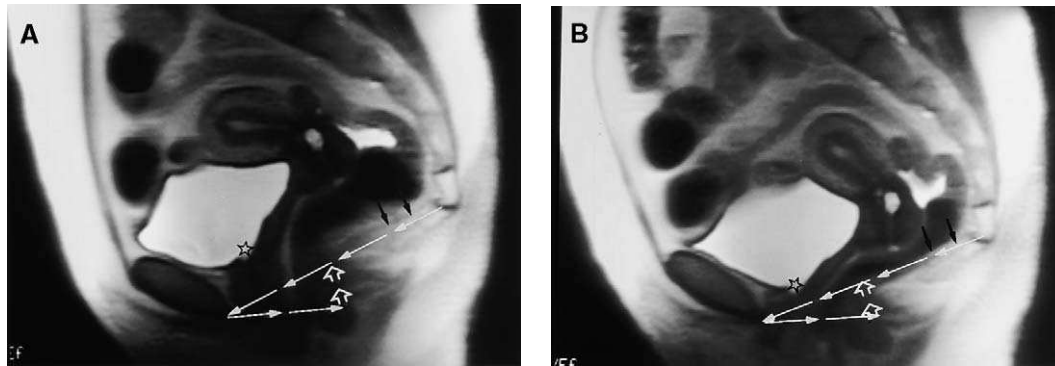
T2-weighted (2200/96) pelvic MR image of a 46-year-old healthy, continent volunteer. Sagittal images of the subject at rest (A) and at strain (B) show minimal inferior movement of the pelvic viscera. The bladder neck is marked with a star. The levator plate (black arrows) remains parallel with the pubococcygeal line (upper line of white solid arrows). The H (lower line of white solid arrows) and M (open arrows) lines are less than 5 cm and 2 cm, respectively, which indicates an intact levator hiatus. (From Fielding JR. Practical MR imaging of female pelvic floor weakness. *Radiographics* 2002;22:295–304; with permission.)
